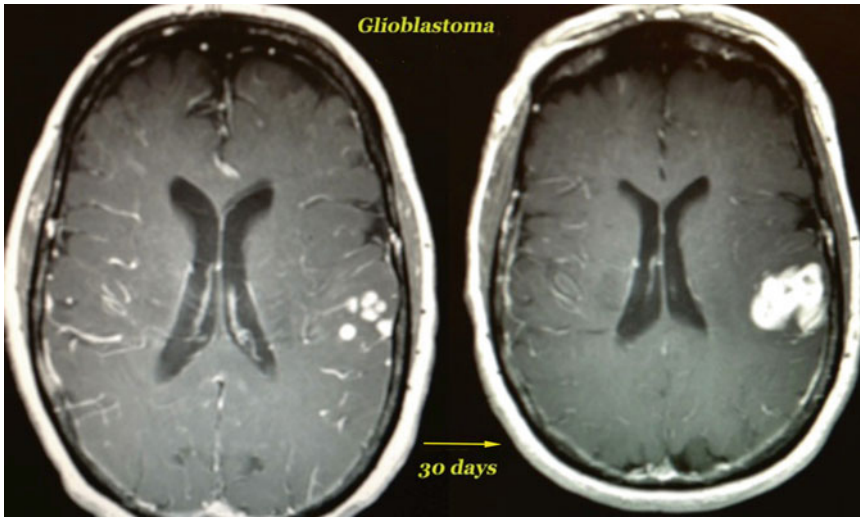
Glioma growth is typically very rapid, as shown by this case example using contrast enhanced MRI in a 75-year-old with new onset of right facial numbness
